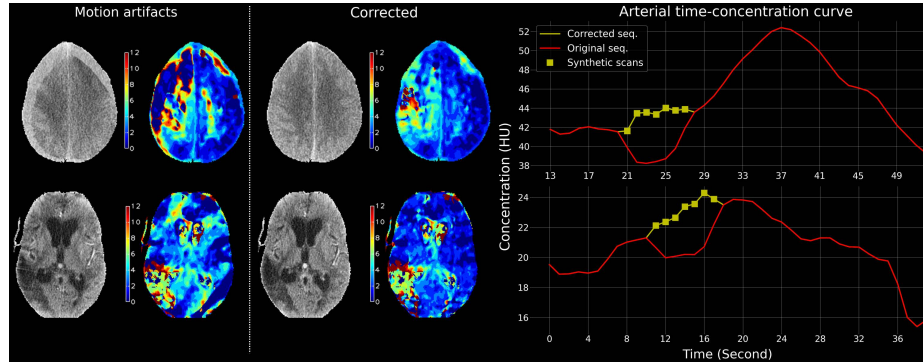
Left: CT scans and corresponding Tmax maps, before and after the motion correction using our model. Right: Arterial TCCs used to compute the Tmax maps, before and after the correction. (Color figure online)
